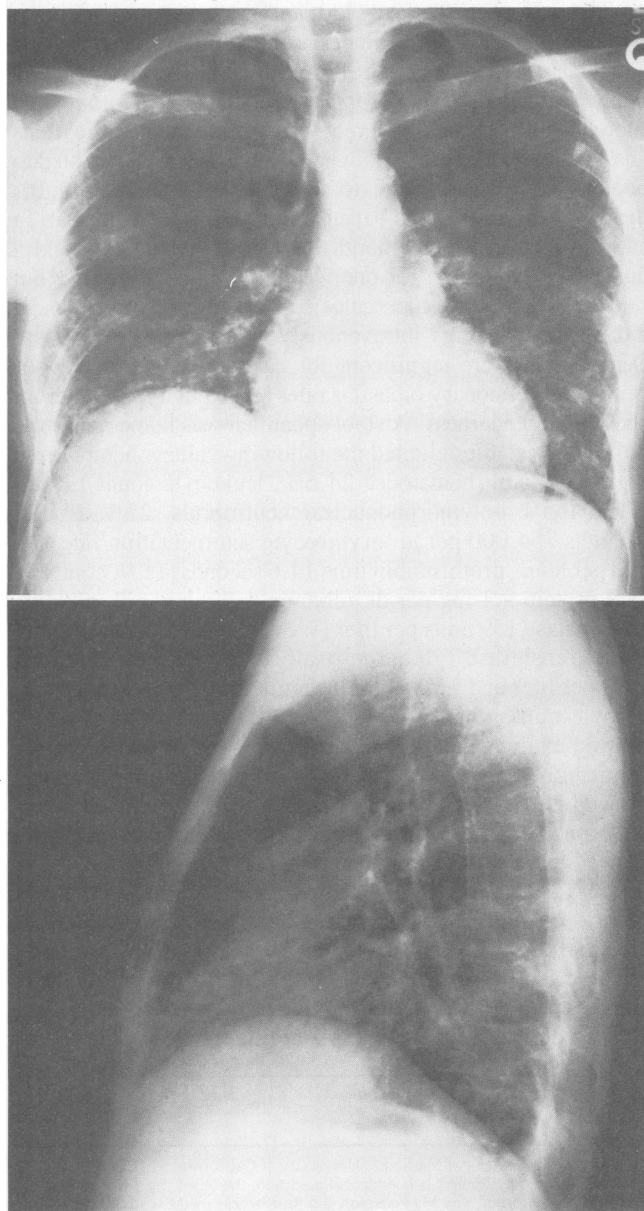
Chest x-ray films, posteroanterior (top), and lateral (bottom), show bibasilar multinodular infiltrates.
